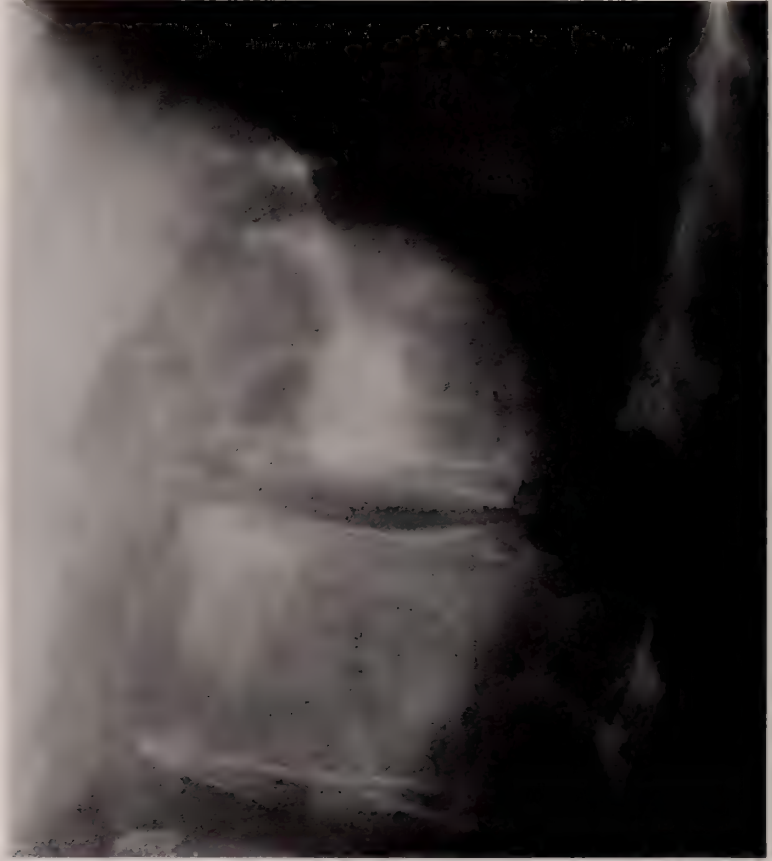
Hodgkin's Disease. There is anterior marginal erosion of the body of the twelfth dorsal vertebra. At the margin of the invading lymphoma there is an osteoblastic reaction. The intervertebral discs and the upper and lower vertebral margins are spared. No regional soft tissue masses could be demonstrated radiographically. The patient was a 43 year old male who first noticed enlarged glands in his neck in 1956. The initial osseous manifestation occurred in 1958 when mixed changes were demonstrated in his sternum. The vertebral lesion was demonstrated in July 1960 two weeks after his first complaint of back pain. Death occurred in November of the same year.
